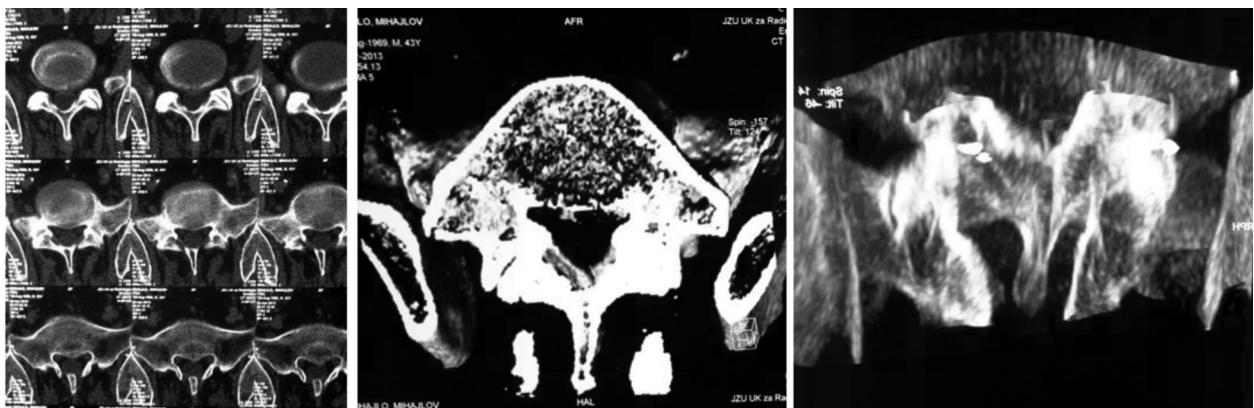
Transverse CT scans demonstrating laminar defect and adjacent spinous process protruding into the defect (left) and 3-D reconstructions at the same level (middle and right)
